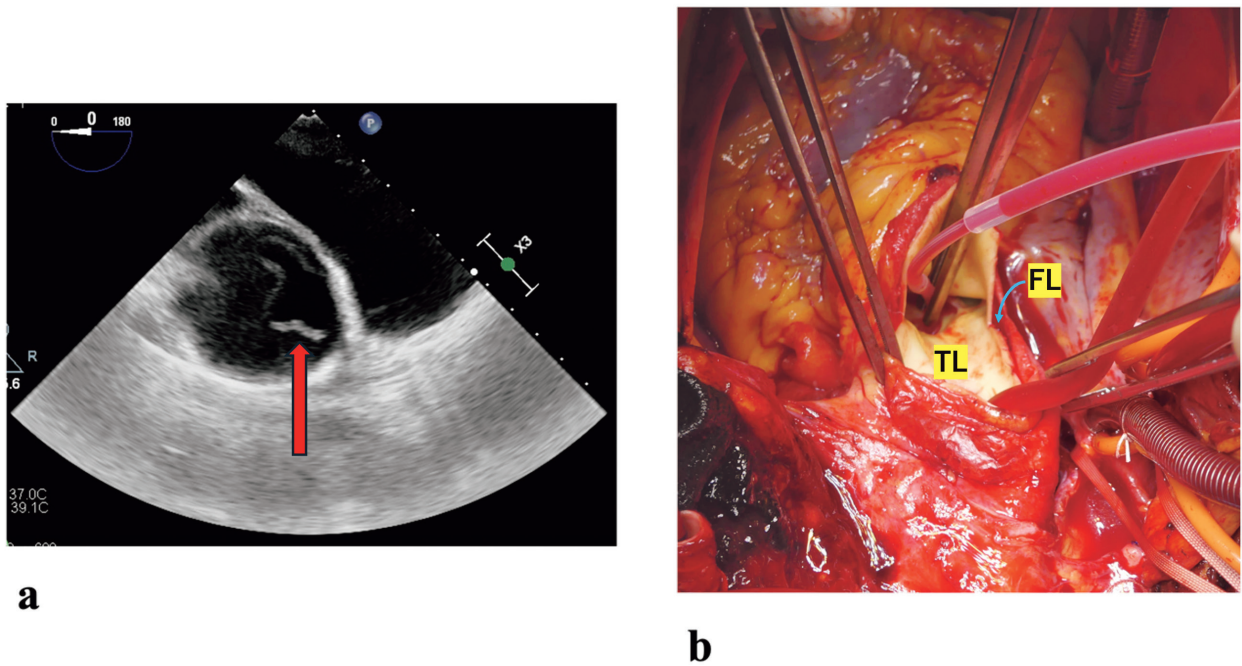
a, Preoperative transesophageal echocardiography detected the dissection of the ascending aorta. The red arrow showed the intimal flap.
